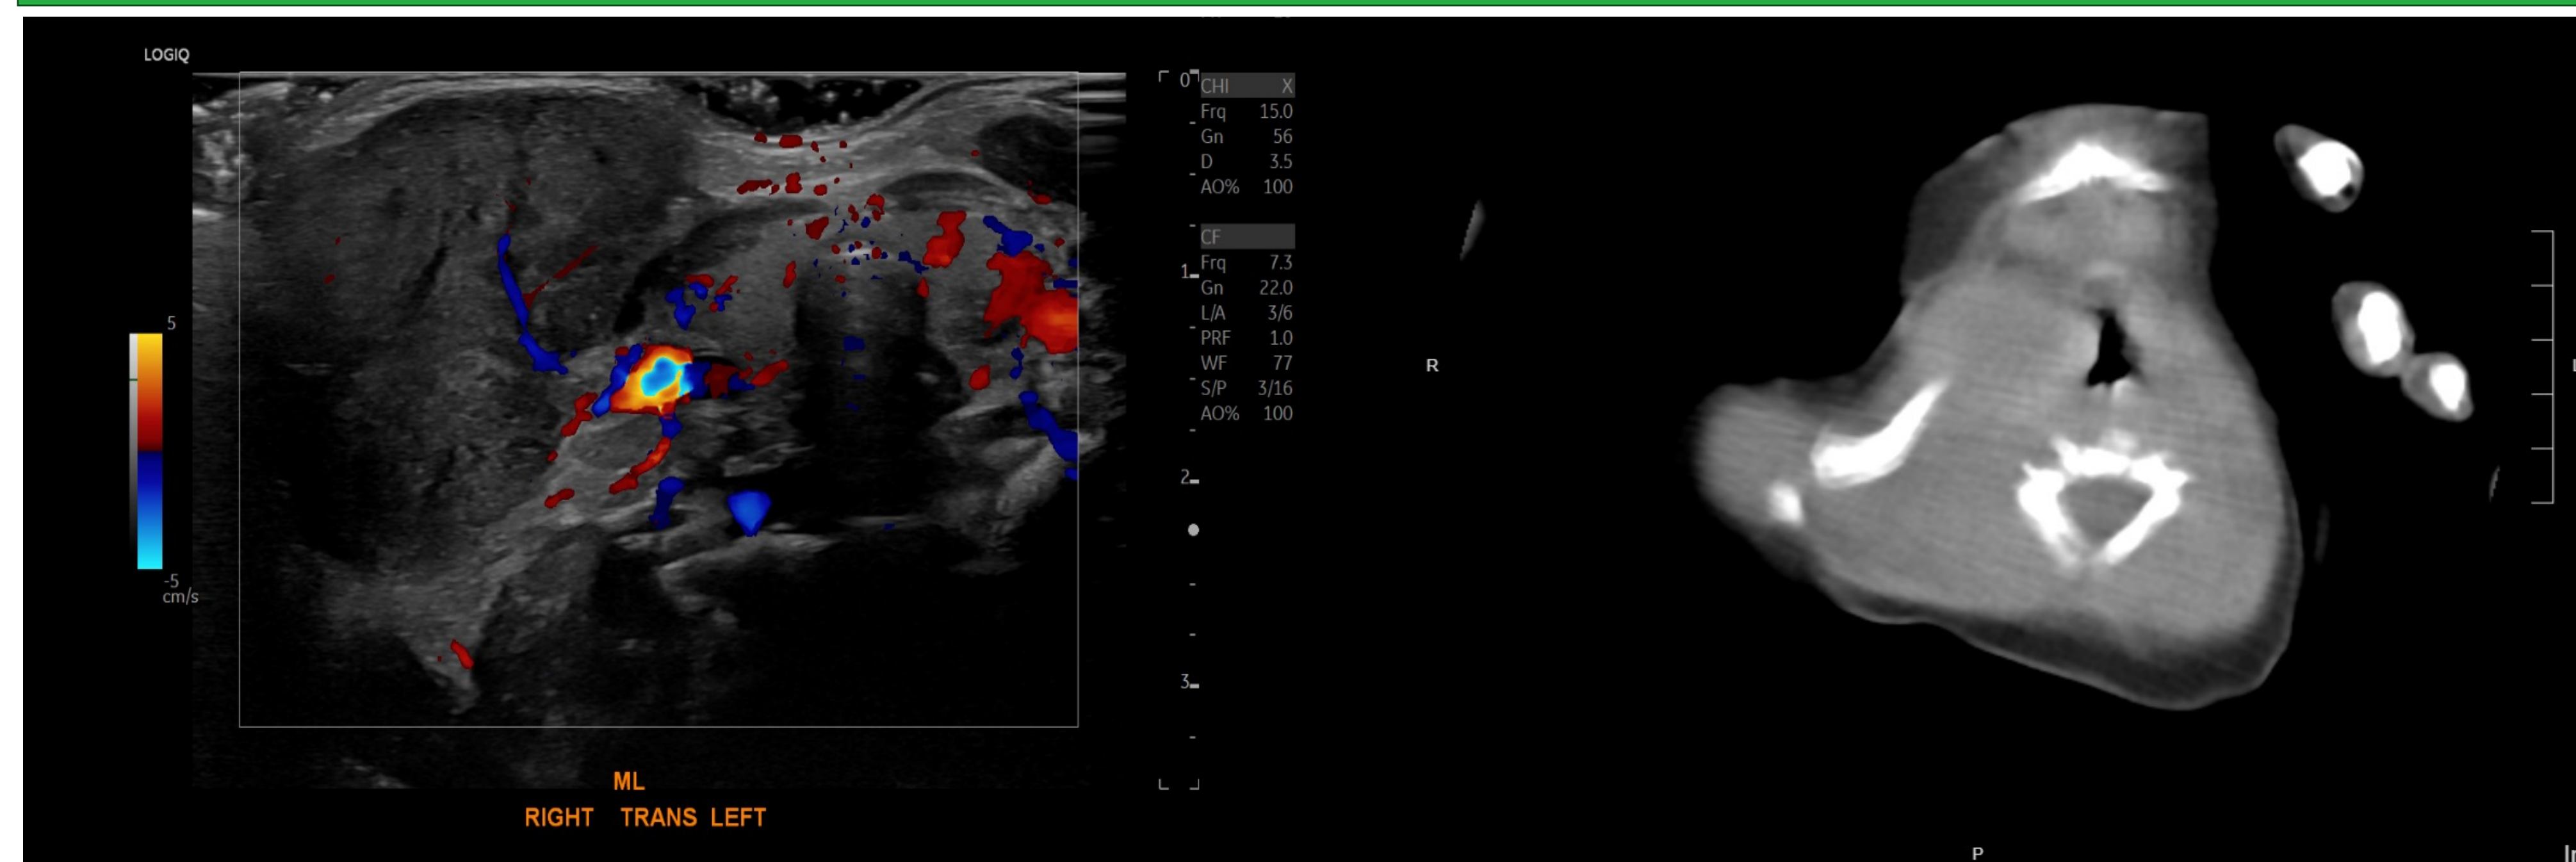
Color Doppler Ultrasound
